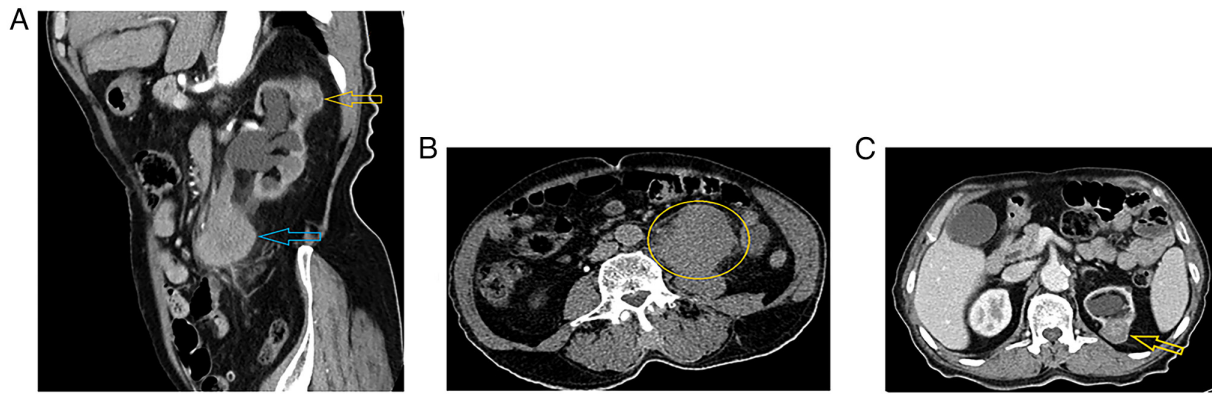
Contrast CT scan of the abdomen and pelvis. (A) Coronal and (B) axial sections of a delayed-phase CT scan with contrast showing a left upper ureteral mass (yellow circle). (C) Axial section showing a left upper pole renal mass (yellow arrows). The blue arrow indicates urothelial cancer in the left upper ureter.
